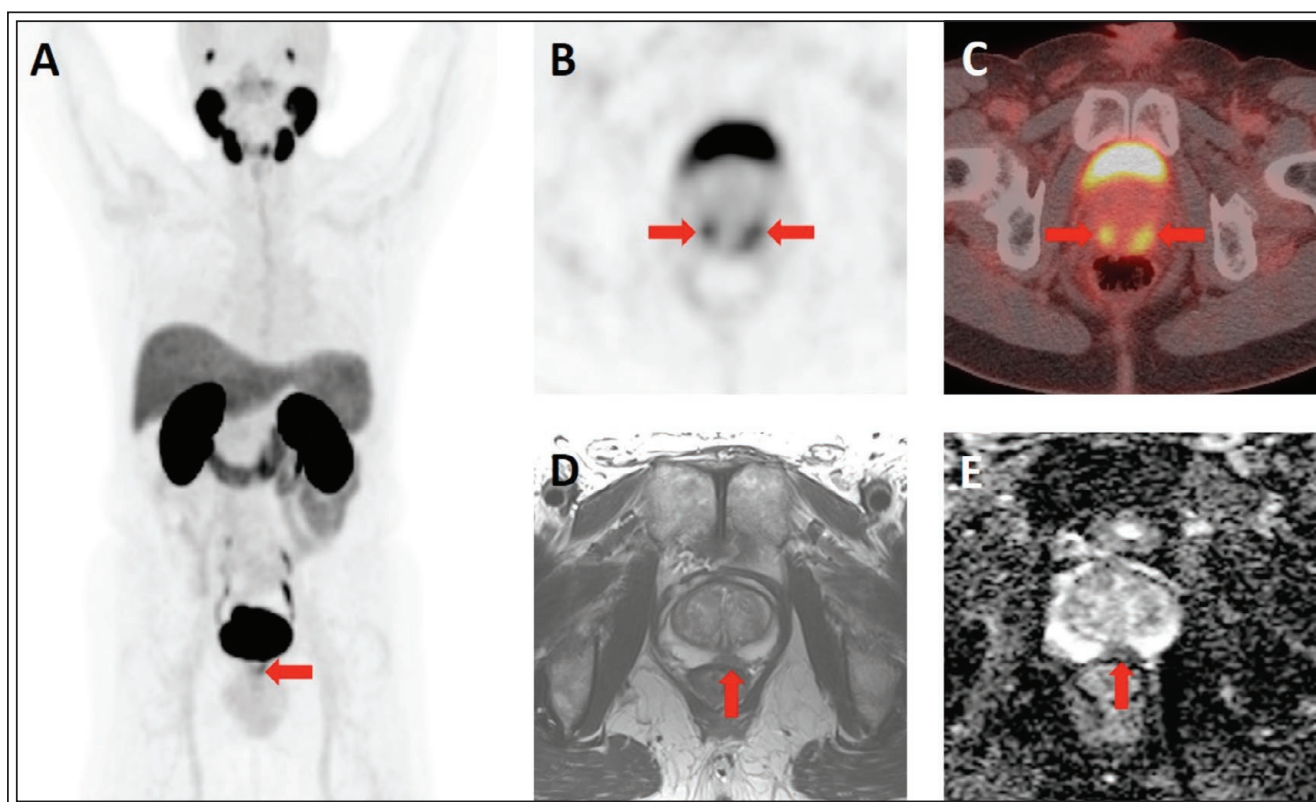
72-year-old man with high-risk prostate cancer. (A) Maximum intensity projection (MIP) ¹⁸F-DCFPyL PET image with corresponding (B) axial PET and (C) PET/CT images demonstrating bilateral abnormal uptake in the base-to-mid peripheral zone of the prostate (arrows). On contemporaneous (D) T2-weighted and (E) apparent diffusion coefficient map magnetic resonance images, the left sided lesion is identifiable as low signal on both sequences (arrows). On surgical pathology, the patient had bilateral disease.
